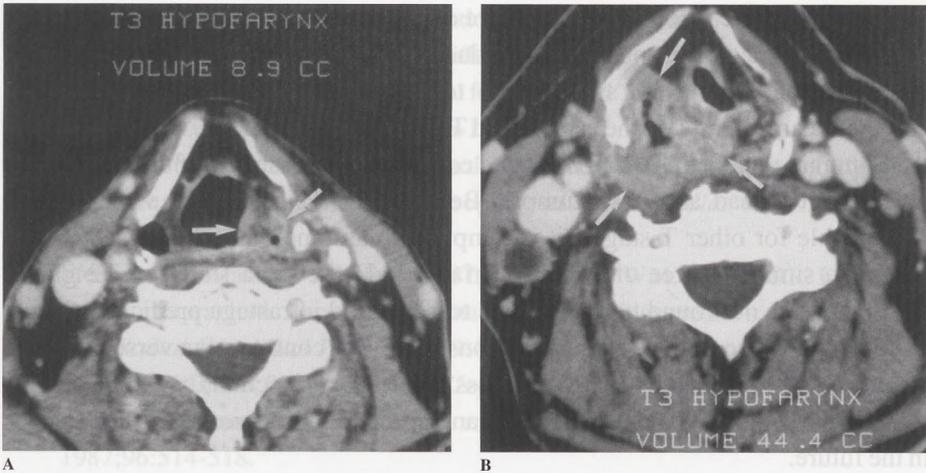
CT axial sections of two different patients with T3 hypopharyngeal (pyriform sinus) carcinoma showing difference in tumor volume of > 100%. (A) Small mass still confined to pyriform sinus (straight arrow); total volume = 8.9 cm³. (B) Large tumor bulk (straight arrows); total volume = 44.4 cm³.
